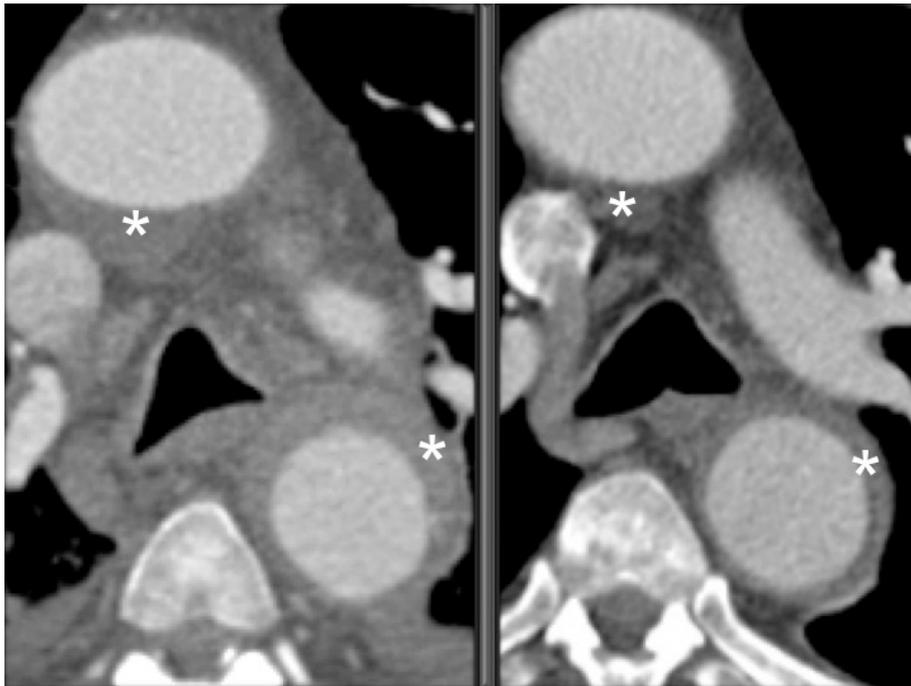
Regression of intramural hematoma (*) documented by computed tomography, 3 weeks after diagnosis (treated conservatively). Notice re-expansion of the true lumen as hematoma regresses.
